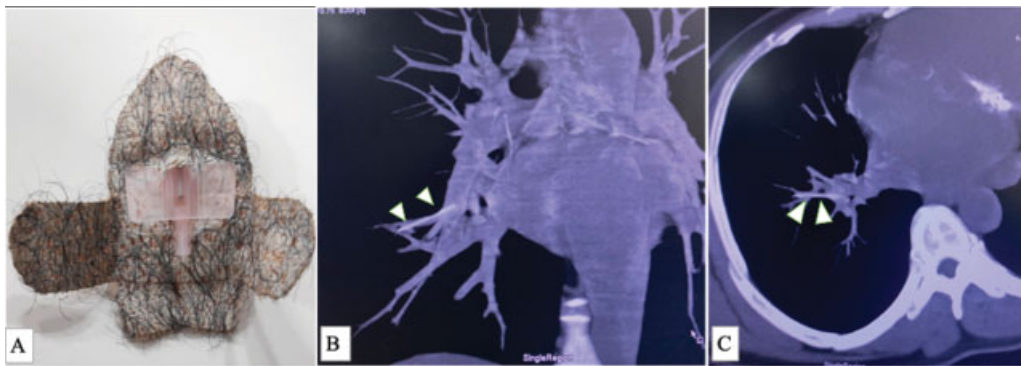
(A) Proximal residual hub of IV cannula. Maximum intensity projections of the CT thorax in (B) Coronal and (C) axial projections showing a linear hyperdense foreign body embolized into anterior segmental branch of right descending pulmonary artery (arrowheads).
